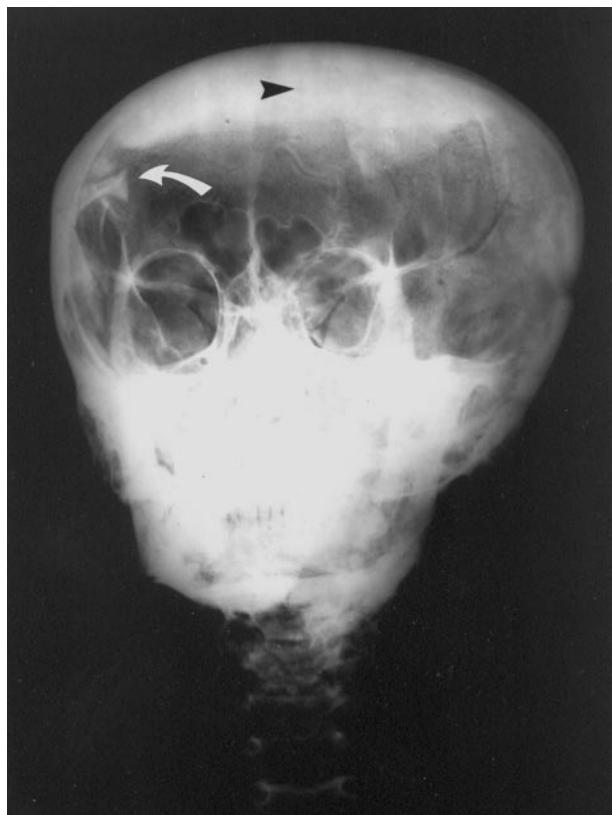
Frontal radiograph of Tutankhamen's skull and cervical spine shows the opaque layer of resin in the vertex region (arrowhead) and the bone fragment (curved arrow). Note that the second fragment is not apparent in this image. (Reprinted courtesy of the University of Liverpool.)
